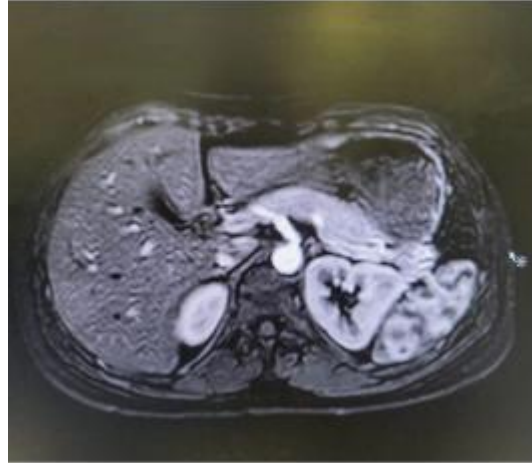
MRI showing pancreas after full recovery
